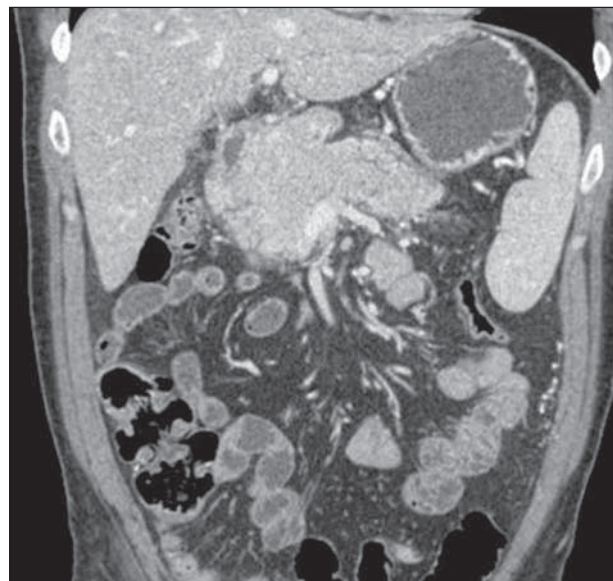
Computed tomographic scan of the abdomen and pelvis.
